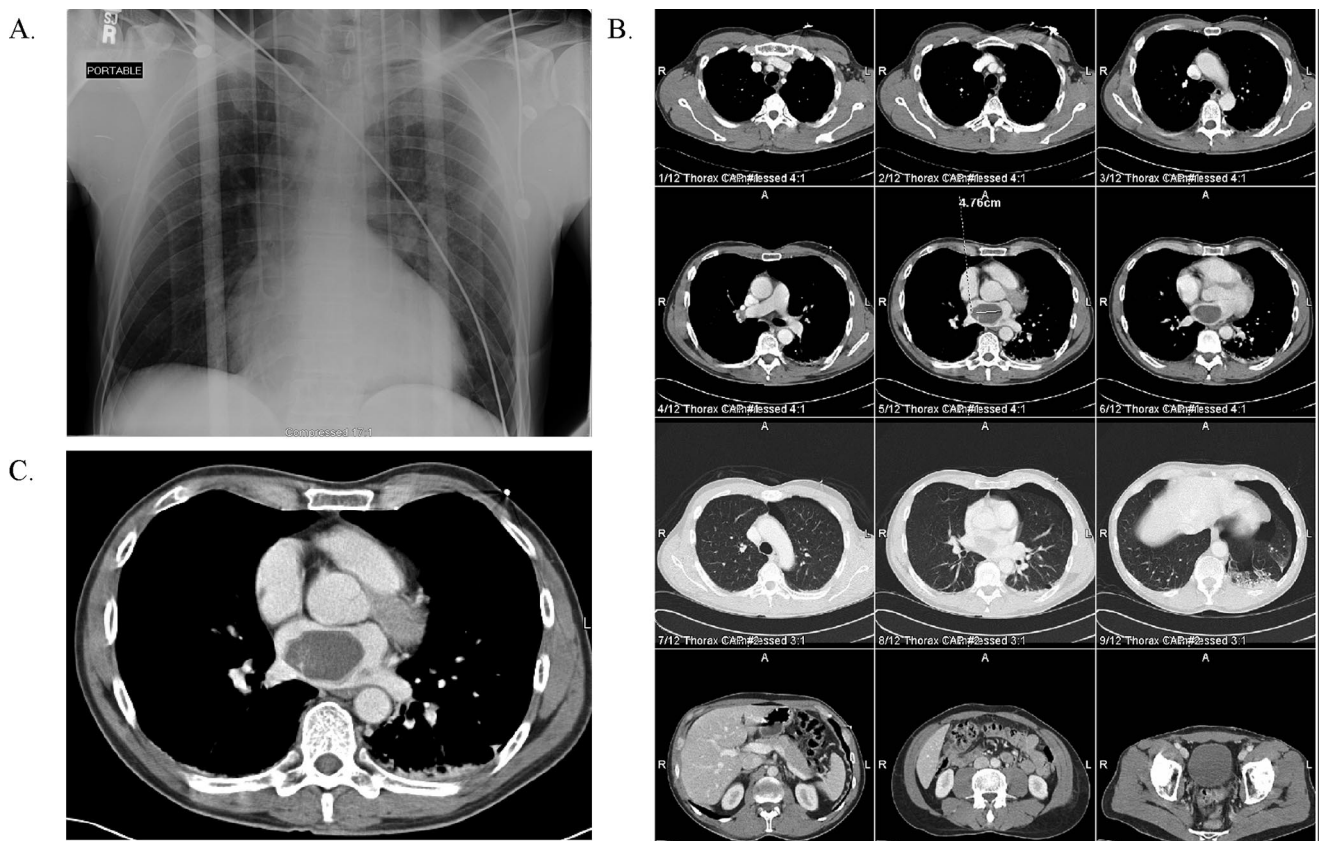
(A) Normal anteroposterior chest radiograph obtained in the trauma room in a 54-year-old man with lower-extremity fracture from a motor vehicle crash. (B) Spiral computed tomography of the chest, abdomen, and pelvis. (C) There is a large asymptomatic left atrial myxoma. The patient underwent successful elective resection 1 month later.
